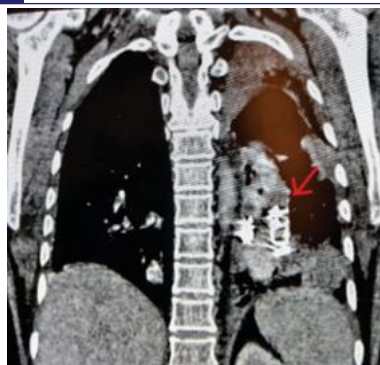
Shows Post Op CT Showing Placement of Vascular Plugs.
